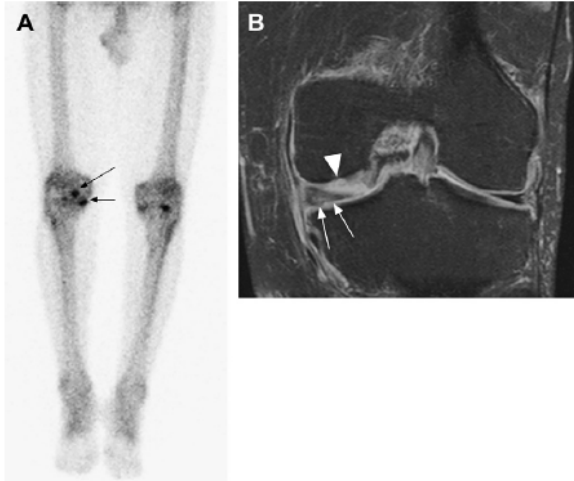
Scintigraphy. (A) Radionuclide accumulation is observed in the medial compartment of the left knee (black arrows) in a patient who has prostate cancer and a high risk for bone metastases. This appearance is nonspecific and more likely secondary to degenerative disease. (B) Coronal T2-weighted fat-suppressed MR image of the same knee shows meniscal degeneration (white arrows) and cartilage damage (arrowhead). The image confirms normal bone marrow without metastatic deposits. (Image courtesy of G. Mercier, MD, PhD, Boston, MA. Reproduced from Guermazi et al. *Rheum Dis Clin North Am* 2008; 645-687.)
